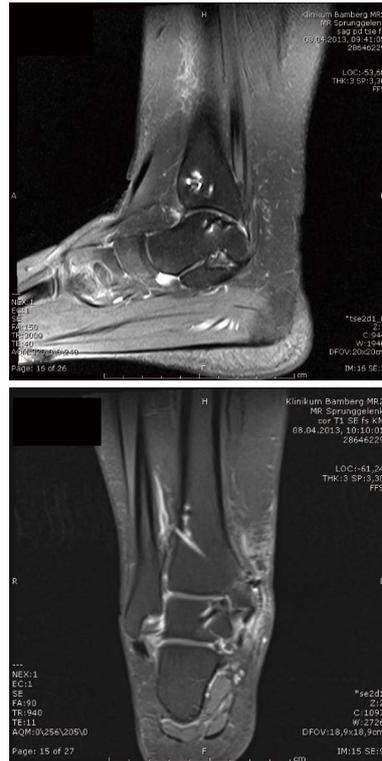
Magnetic resonance imaging 3 mo after the procedure. The bone graft is integrated, the cartilage graft intact and osteotomy closed.
